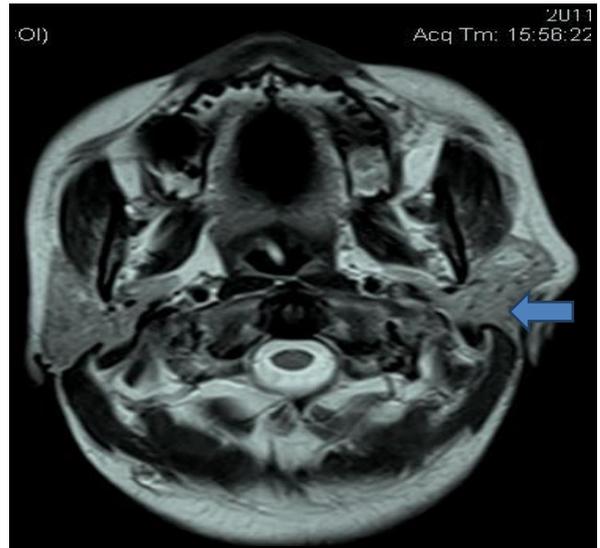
AXIAL T2WI MR image showing inflamed left parotid gland
